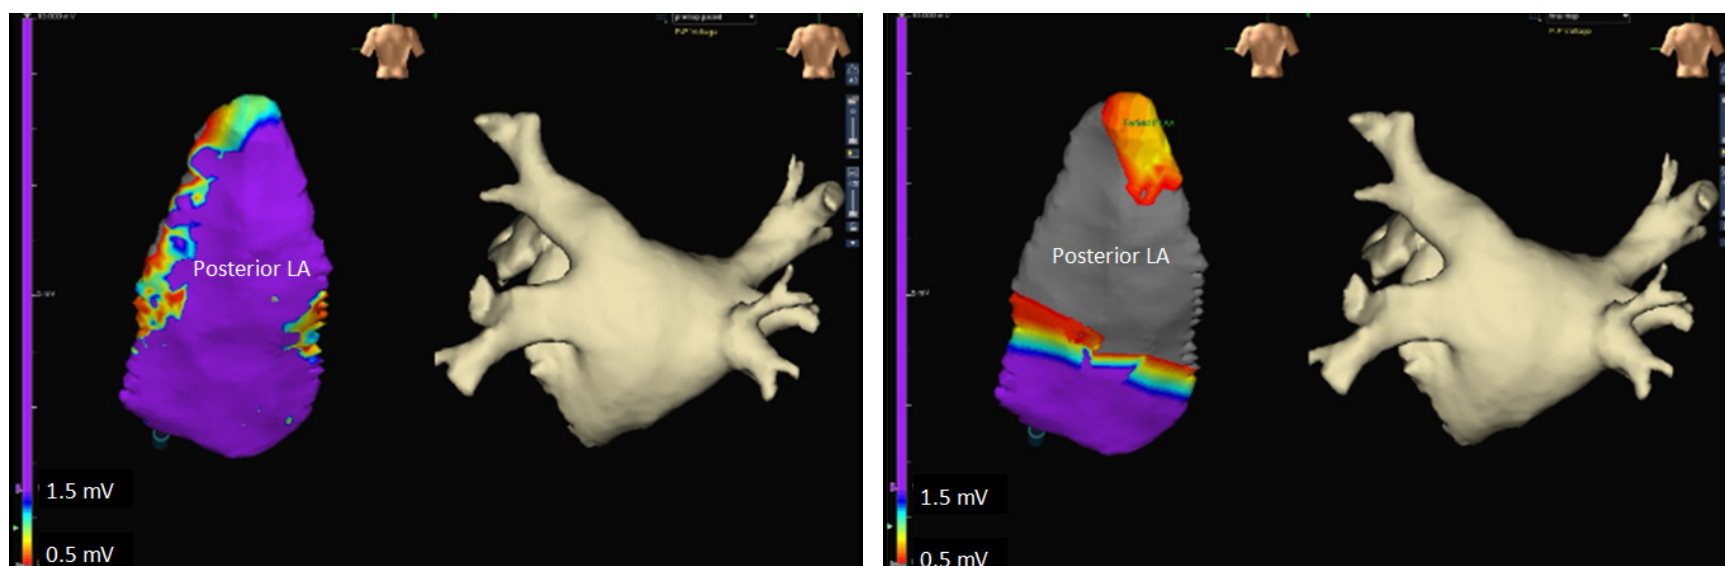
3-D Electroanatomical Map of Epicardial Posterior LA Wall and CT Reconstruction of LA and Pulmonary Veins
